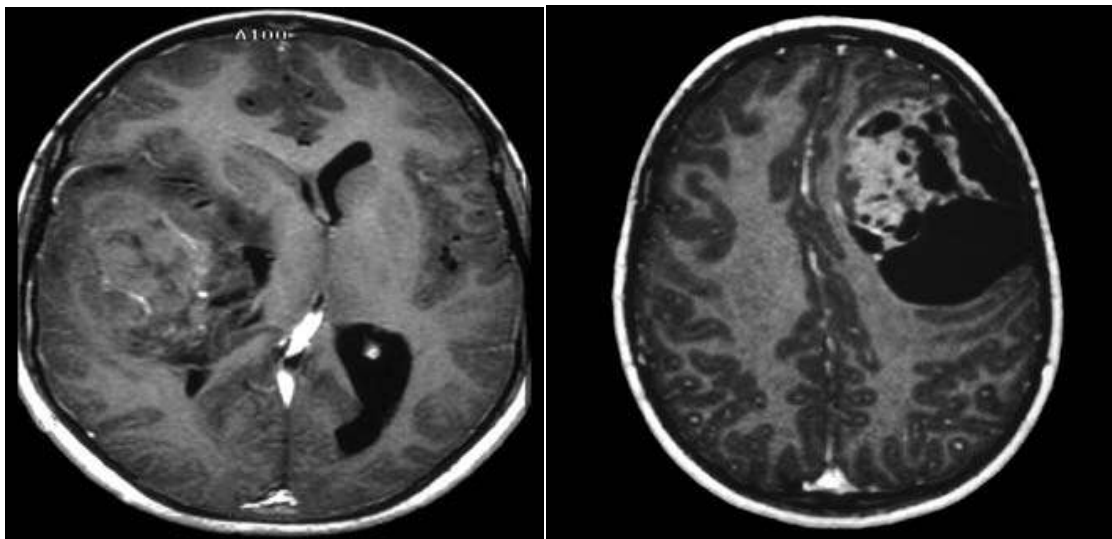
T1-weighted MRI of a large, hemispheric PNET with advanced neuronal differentiation (neuroblastoma). (Left) T1-weighted gadolinium-enhanced MRI of a cystic medulloepitheliomas in the frontal lobe. (Right). (Giangaspero et.al (2007)).
